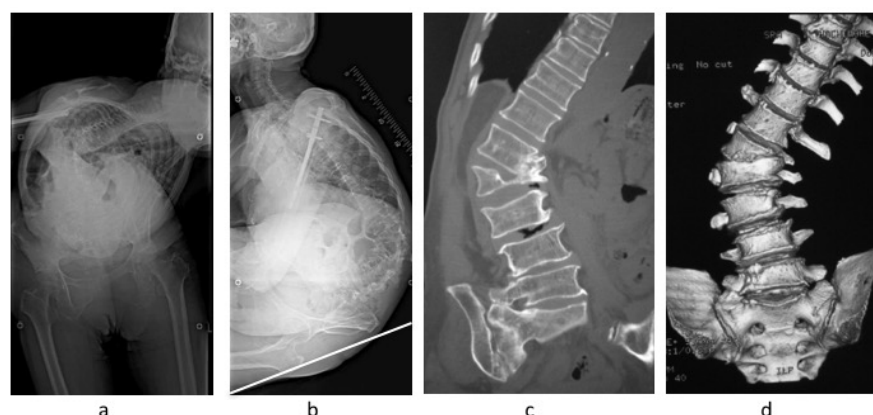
Preoperative standing X-ray and computed tomography. (a) Anterior-posterior radiograph. C7 plumb line was 30 mm lateral to sacral center. (b) Excessive kyphoscoliosis of the thoracolumbar spine is present; the cervical spine is in extension. White line shows gravity line. (c) A vertebral compression fracture is present at L2. (d) L1 vertebra is migrating to L2.
